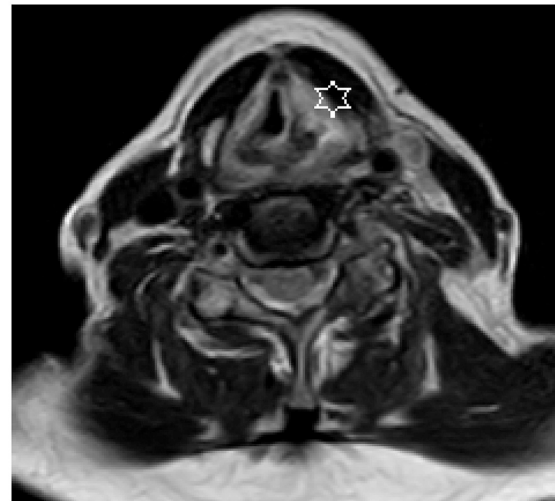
Axial MRI showing unilateral vocal cord paralysis. Star marks unilateral cord paralysis.
